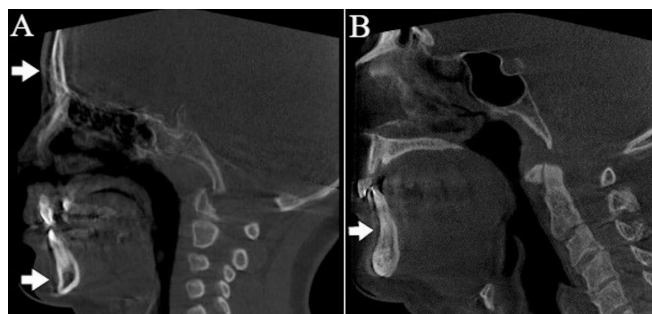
Motion artifact is (white arrows) demonstrated in the sagittal CBCT images (A and B).
